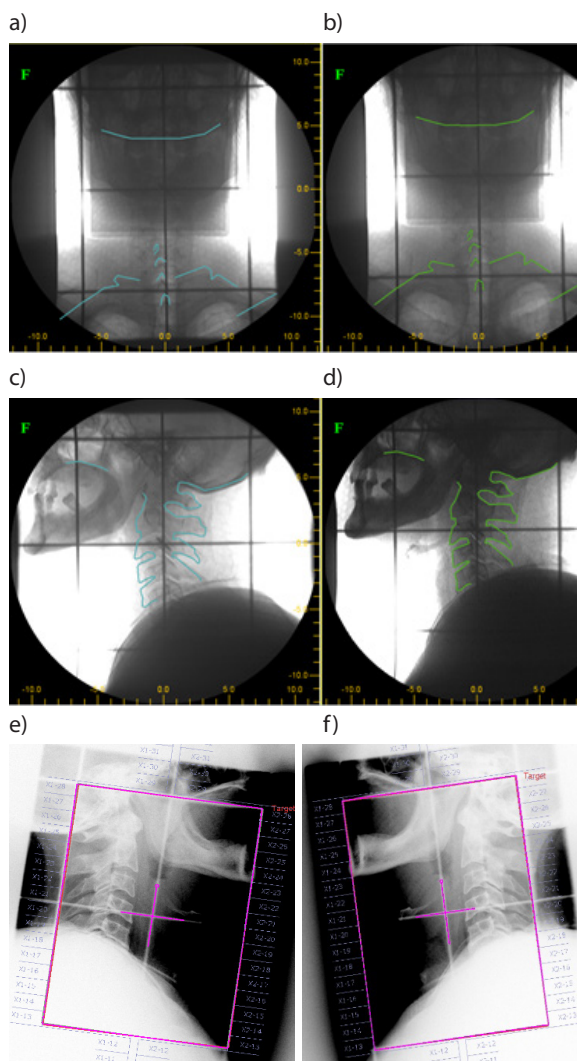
Use of X-ray images to verify a patient’s positioning before starting radiation therapy (a, b, c, d) and in two-dimensional planning (2D) of radiation therapy (e, f). Photographs a and c are reference images, while photographs b and d are verification images. In order to determine the mutual position of the fields in both pictures, the same anatomical structures were marked. The next step is to superimpose the images on each other and read the shifts along the x, y, z axes
